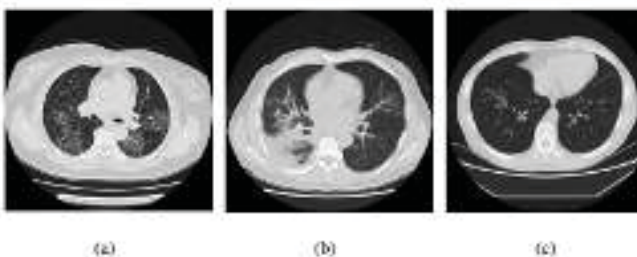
(a)CT lung image with COVID-19 (b) CT lung image with other pneumonia (c) healthy CT lung image
